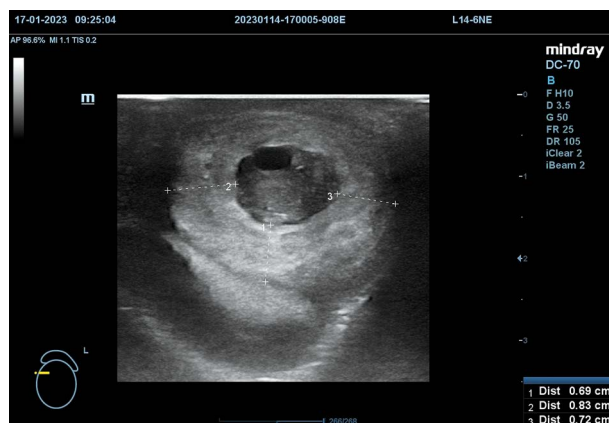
Ultrasound image of the scrotum on the left side with visible oedema of the scrotum wall, up to 8.3 mm. The testicle is visible in the transverse view. At 12 o'clock, a visible transverse view of the cyst in the epididymis area. Mindray ultrasound machine, L14-6NE transducer. Examination performed by MWM
